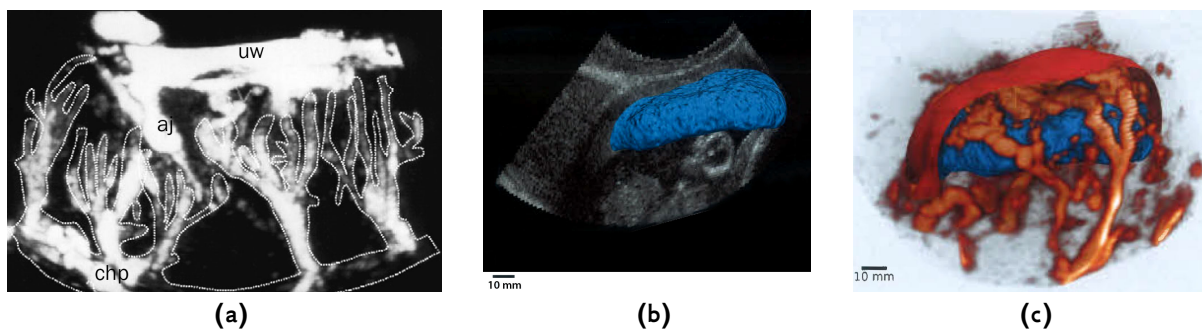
(a): 3-D power Doppler scan of a placentone of a healthy human placenta at 38 weeks of pregnancy. In the figure: the chorionic plate and the villous tree (chp, outlined in white), the uterine wall (uw) and jets of maternal arterial blood entering the IVS (aj). Reproduced from Konje et al. (2003). (b): 3D segmentation of the placental volume based on 3D B-mode (brightness mode) ultrasonographic pictures. (c): 3D rendering of the moving blood volume obtained with 3D Power Doppler ultrasound (orange) plotted over the segmented placental volume of (b). The fraction of moving blood volume is then estimated as the ratio of the volumes of the orange and blue components. The uteroplacental interface is shown in red. Both pictures reproduced from Stevenson et al. (2015)
